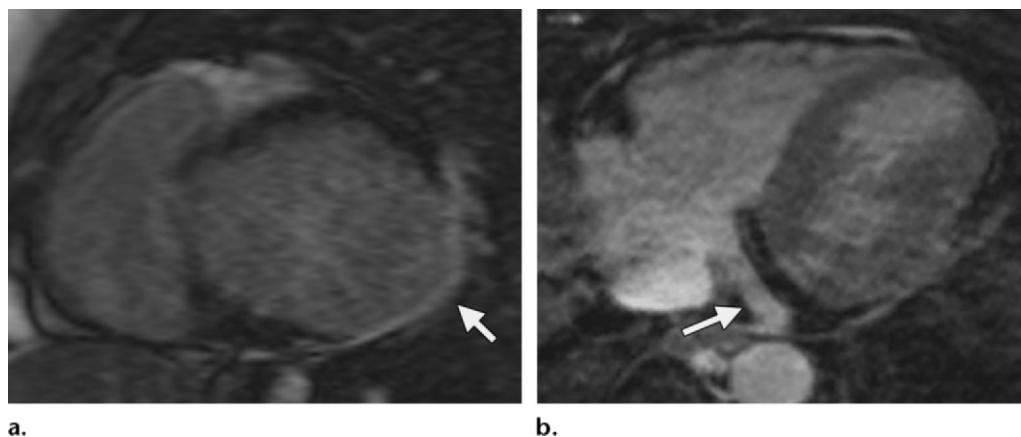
MR imaging in cardiac resynchronization therapy. (a) Short-axis delayed-enhancement image in a 47-year-old man being considered for cardiac resynchronization therapy shows extensive full-thickness transmural scarring in the anterolateral and inferolateral segments (arrow), which is associated with poor response after cardiac resynchronization therapy. (b) Image from 3D whole-heart coronary venography shows the venous anatomy of the heart, which is useful in planning coronary resynchronization therapy. Arrow = coronary sinus.
